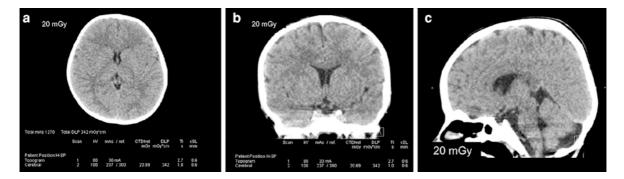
Optimized Brain CT acquisition in a 8-year-old boy with 100 kV, activated AEC and image quality set at 300 mAs. The resultant tube current time product is at 237 effective mAs
